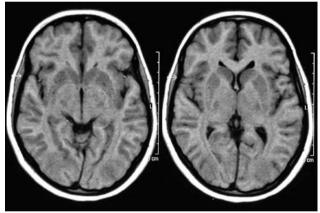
Axial T1-weighted MRI images.
